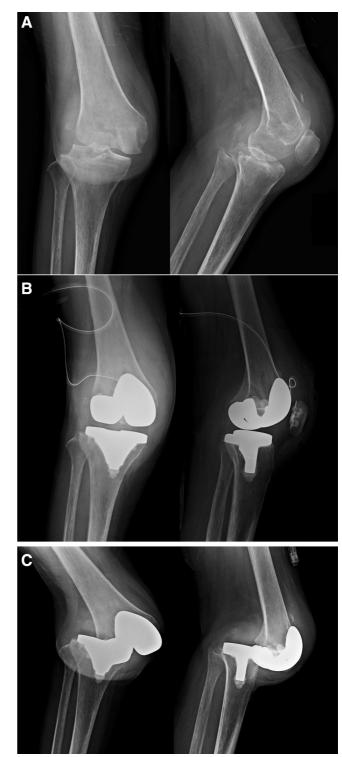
This is a 51-year-old female patient with history of old septic arthritis of the right knee. A, Preoperative AP and lateral plain film shows severe bone loss over the lateral condyle; B, Postoperative plain film; C, Postoperative 3-month plain film shows persistent dislocation of the joint.
